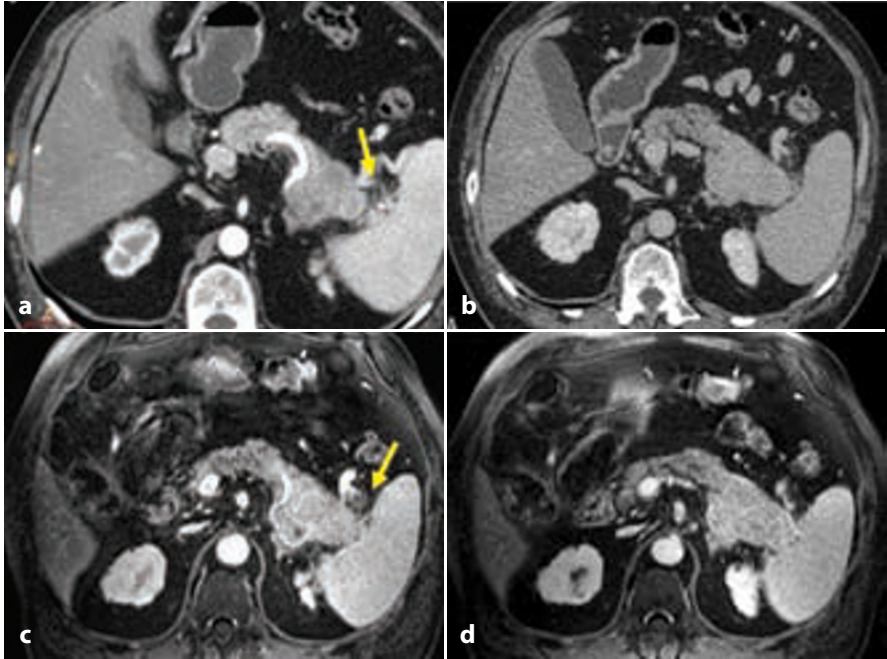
Infiltration of adjacent structures as assessed using MDCT (a, b) and MRI (c, d). A large inhomogeneous NF-PanNEN/C of the pancreatic tail infiltrates the splenic hilum and peri-pancreatic fat (*arrow*), as well-depicted with both modalities
